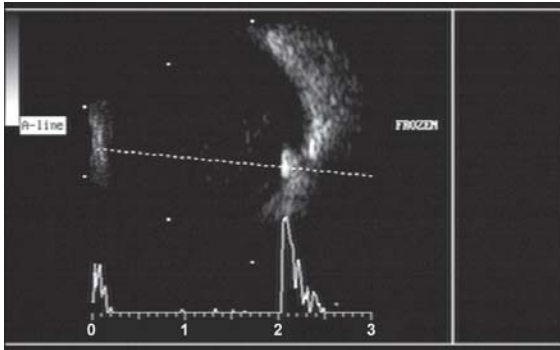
Ultrasonography showing IOFB
